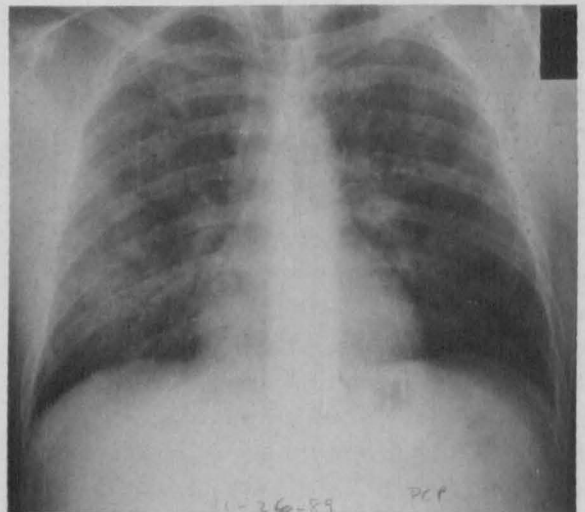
Posteroanterior chest radiograph of a patient with *Pneumocystis carinii* pneumonia showing diffuse bilateral reticular infiltration.
